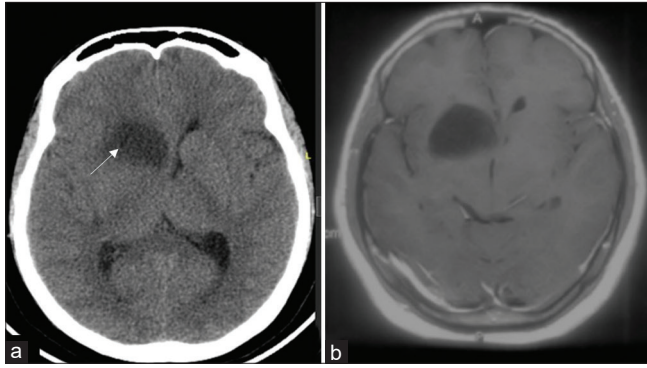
(a) Post procedure plain computed tomography showing lesion location in relation to the anterior limb of right internal capsule as an indirect evidence at corresponding cuts with white arrow indicating biopsy site. (b) In an index case of the right caudate glioma, preoperative contrast magnetic resonance imaging sequence.
